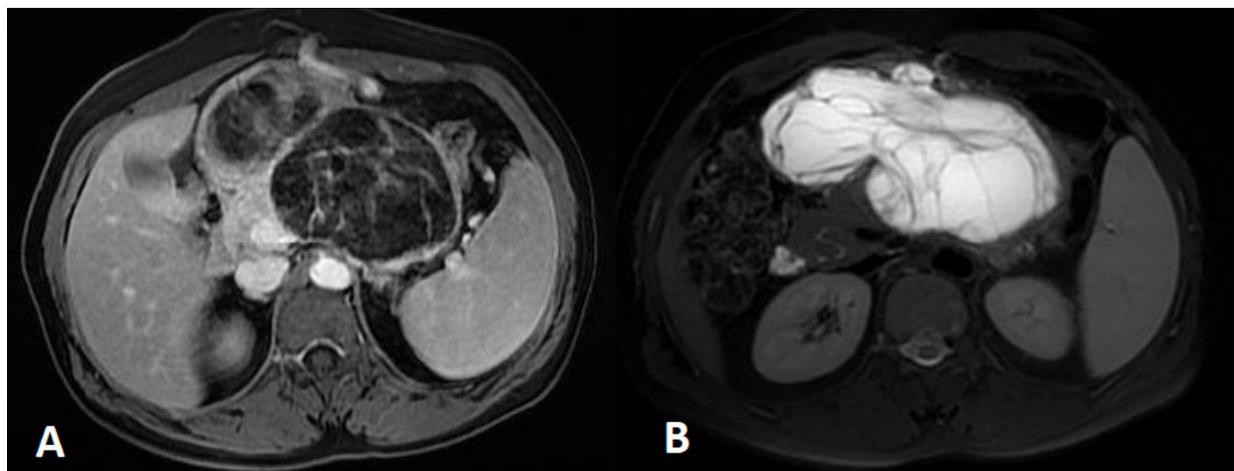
MRI showing a partitioned cystic mass of the body of the pancreas. A: T1-weighted fat-saturated post-gadolinium image, B: T2-weighted fat-saturated image
